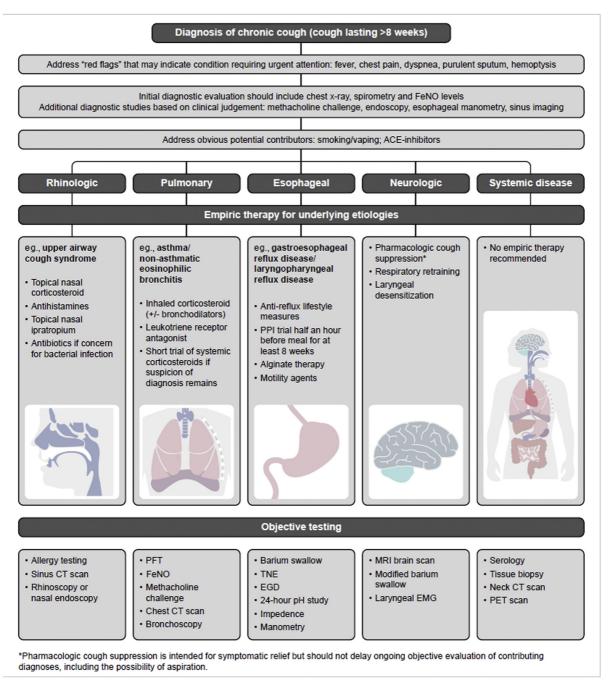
Example diagnostic-management protocol aimed at treatable underlying etiologies of chronic cough. ACE, angiotensin-converting enzyme; CT, computed tomography; EGD, esophagogastroduodenoscopy; EMG, electromyography; FeNO, fractional exhaled nitric oxide; MRI, magnetic resonance imaging; PET, positron emission tomography; PFT, pulmonary function test; PPI, proton pump inhibitor; TNE, transnasal esophagoscopy.
